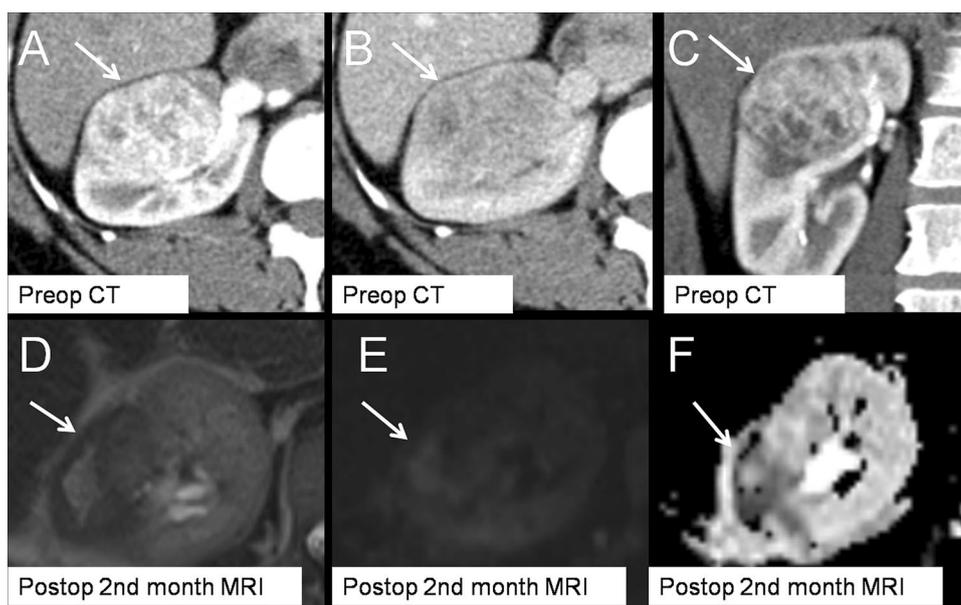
A 38-year-old woman with a large solid renal mass in CT, whose pathology results indicated clear cell-type RCC (arrows) (a–c). A gelatin-based agent (Spongostan[®]) was used in the PN. In the second month follow-up MRI, there is a MLL (a bolster-related mass) at the operation site, which has a T2 hypointense rim (arrow) (d). High-*b* value diffusion-weighted image (e) and ADC map (f) shows linear diffusion restriction areas in that mass (arrows)
